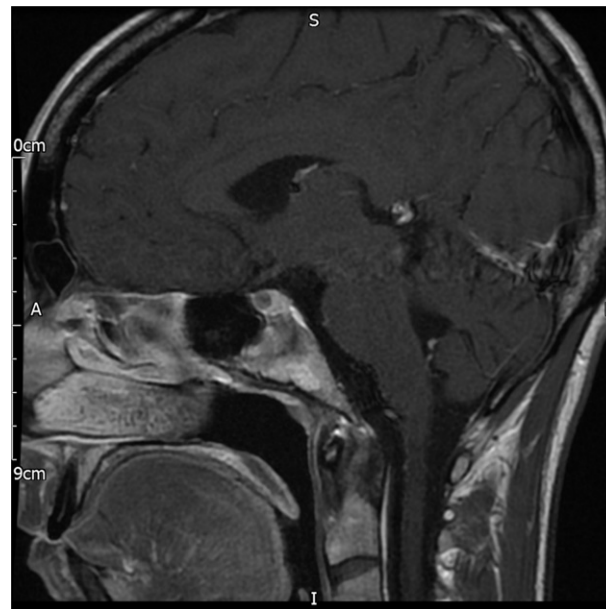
MRI pituitary, sagittal view with contrast. Serum prolactin 1614 mU/L. The small low signal lesion within the pituitary gland is characteristic of a microprolactinoma.
